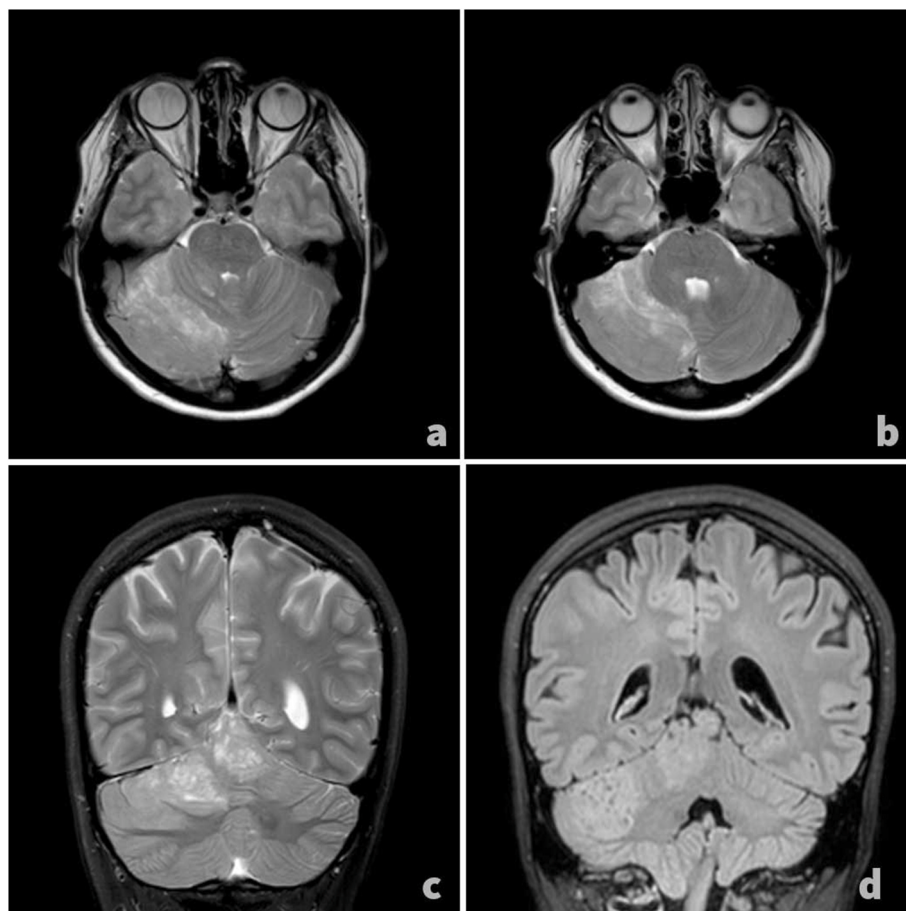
A preoperative T-2 weighted and FLAIR-weighted MRI scan in axial (a) and coronal (c) reformation revealed a characteristic striate, laminar tiger pattern lesion of cerebellar parenchyma in the right hemisphere and vermis area indicative of dysplastic cerebellar gangliocytoma (a-d). Compression of the fourth ventricle was also observed, leading to a slight lateral ventricular enlargement (c).
